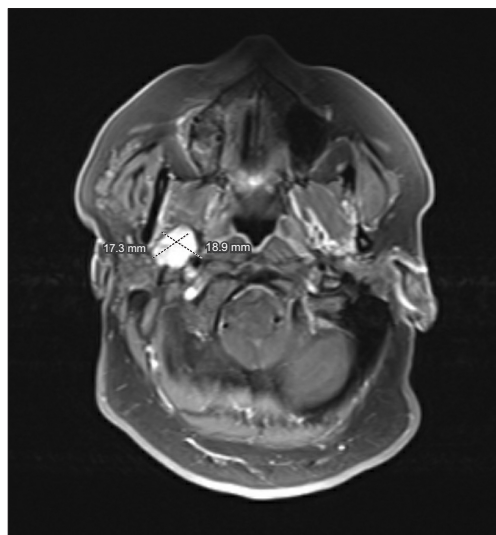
T2-weighted magnetic resonance imaging demonstrating a right sided parapharyngeal space tumor.
